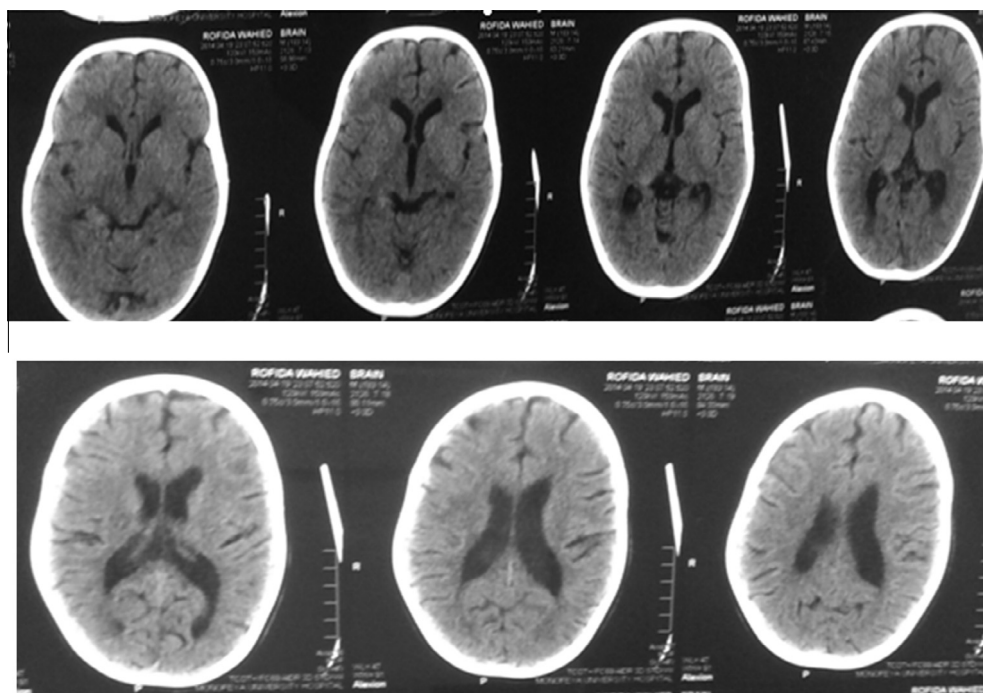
CT brain showing normal findings, no abnormal density.
